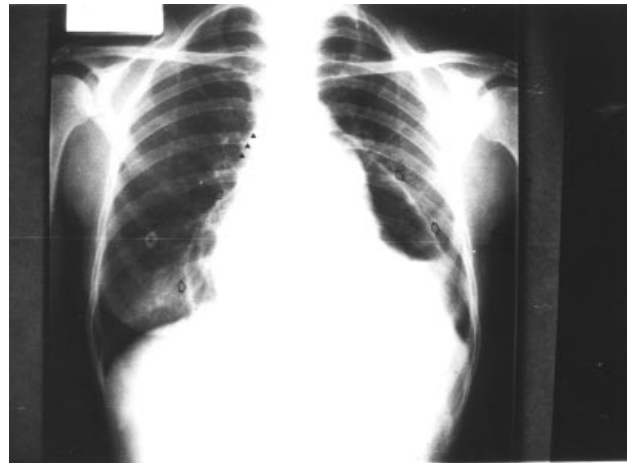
The chest X-ray revealed that there were two obvious radiolucent areas along both heart borders with intrapericardial fluids, suggesting pneumopericardium (open arrows). It also showed a thin radiolucent area outlining the right mediastinum, suggesting possible pneumomediastinum (arrow heads).
